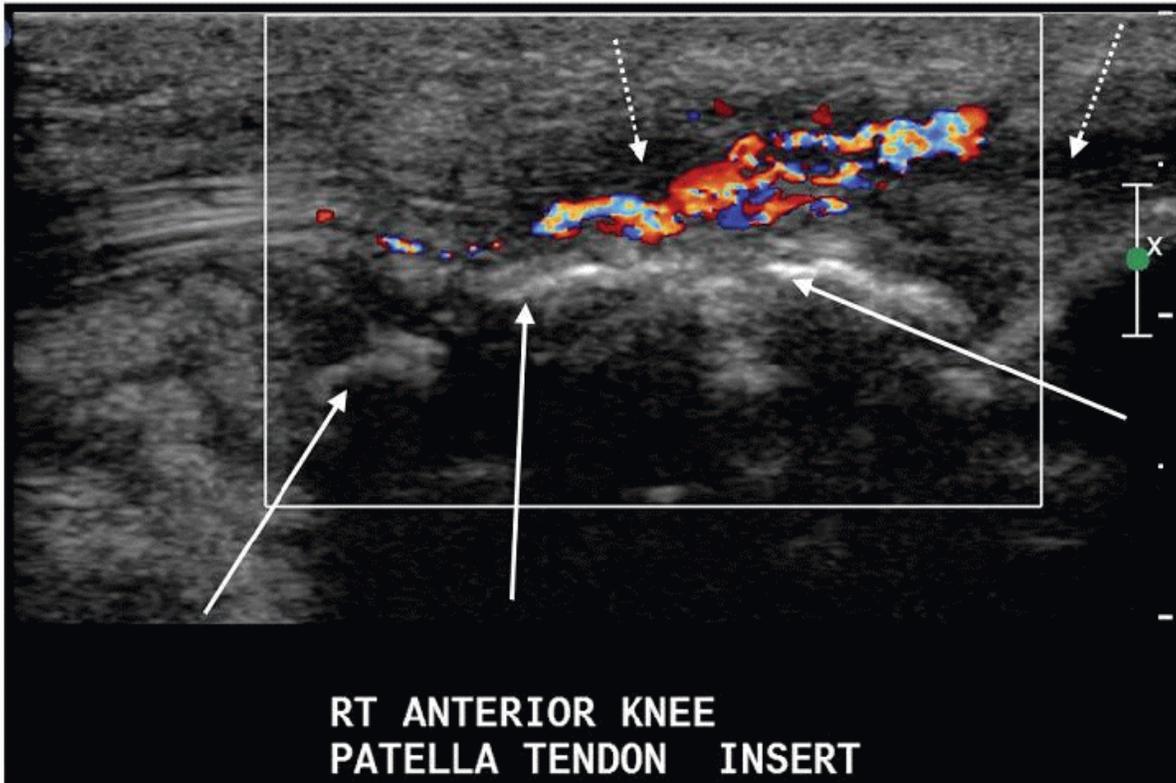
Longitudinal color Doppler image of the patellar tendon insertion in Osgood-Schlatter disease. Solid arrow, fragmented tibial apophysis. Dashed arrow, swollen tendon and hyperemia.
